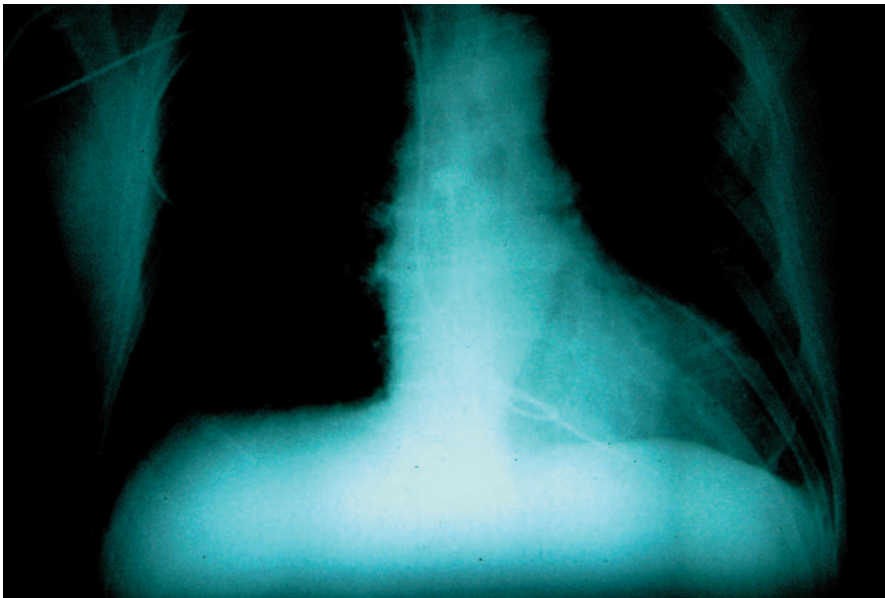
X-ray chest shows a knot in the pacing wire.
